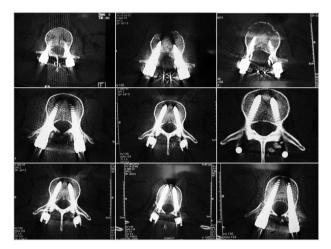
Post-operative plain x-rays are adequate to confirm the proper placement of the screws. In AP view the tip of the pedicle screws should remain lateral to midline. In lateral view the arch of the intervertebral foramen should be maintained. Thin cut CT-scan is the best way of confirming position of the pedicle screws.
